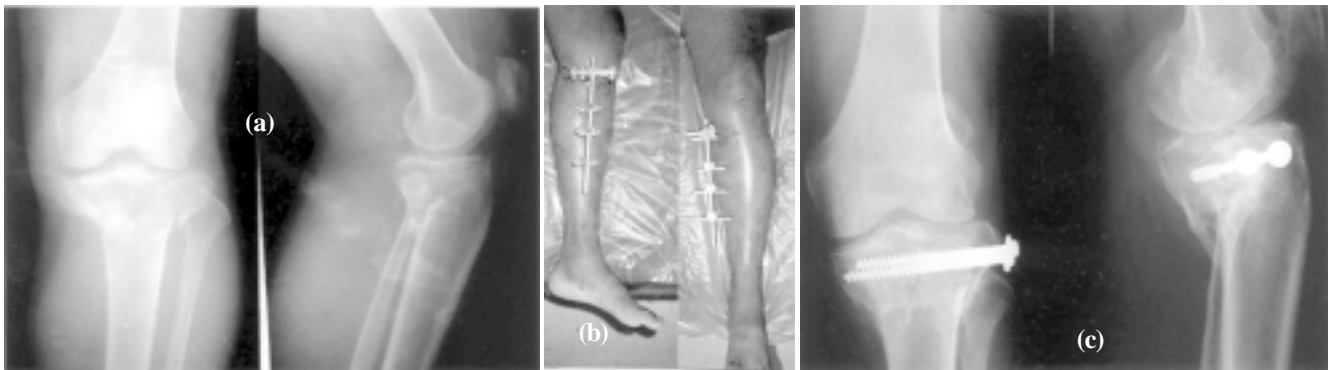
(a) Radiograph showing Schatzler gr. VI fracture; (b) after fixation with T clamp and external fixation with limited internal fixation; and (c) after union.
